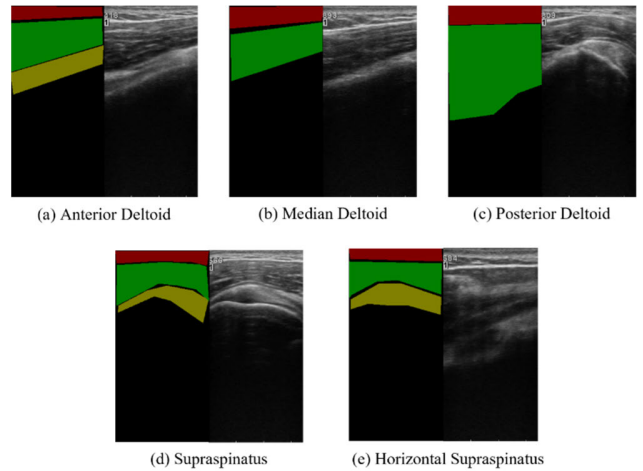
Each picture demonstrates the labeled picture (left side) and the original ultrasound image (right side). Red stands for the subcutaneous tissue, green is the muscle, and yellow is the tendon.
